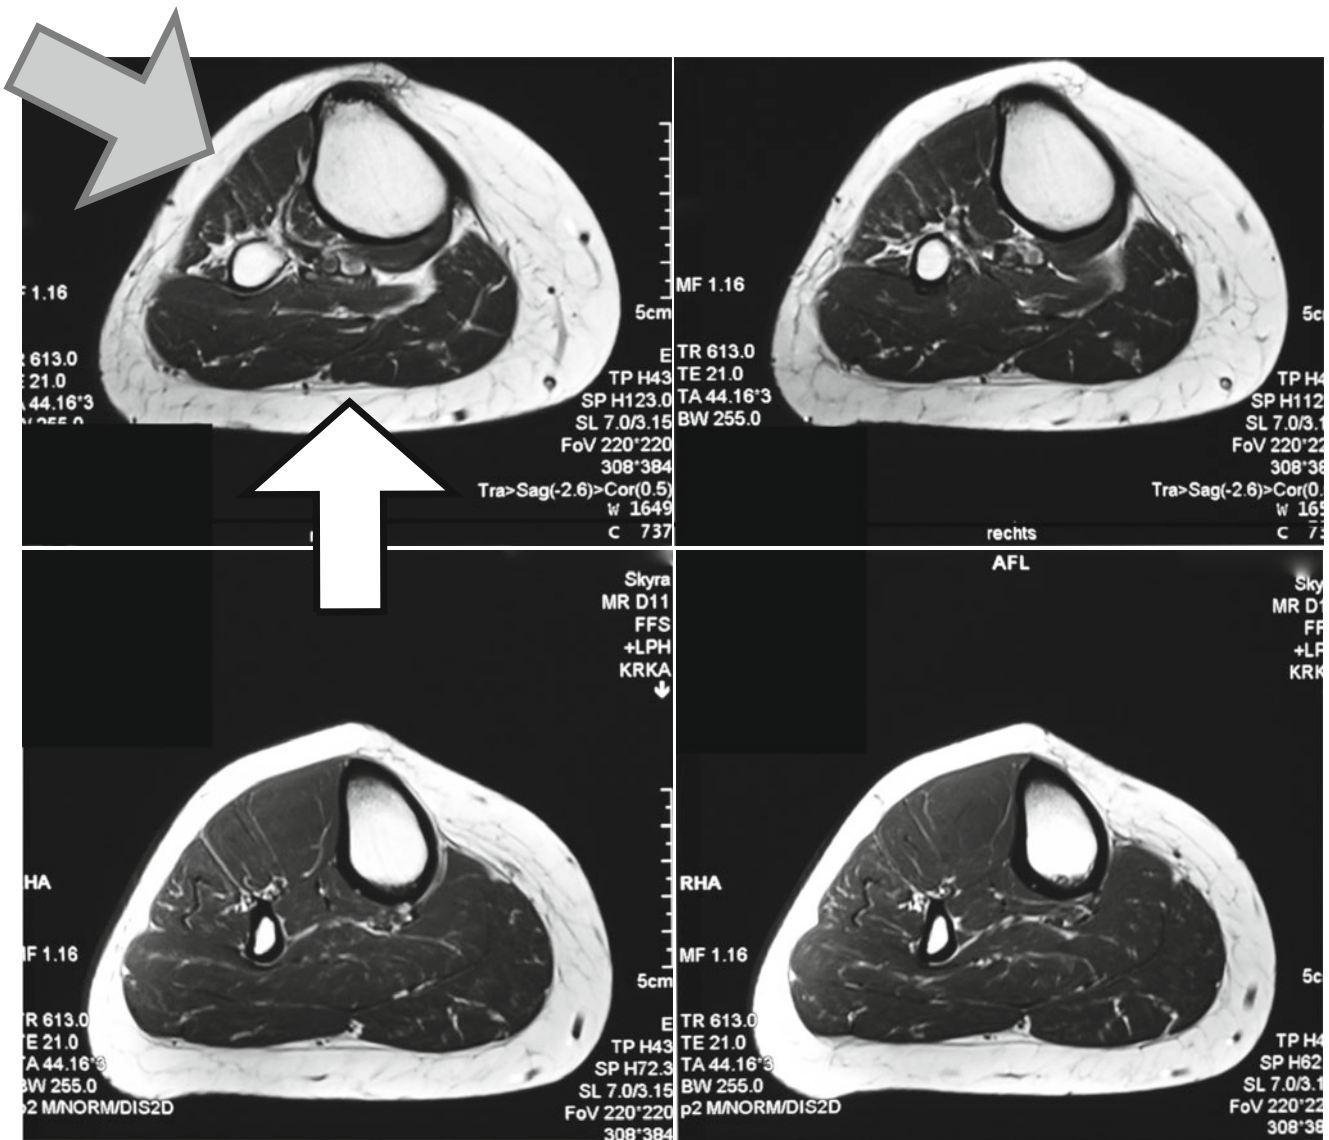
Calf muscles. MRI of normal calf muscles: *Gray arrow* anterior compartment. *White arrow*: calf muscles
